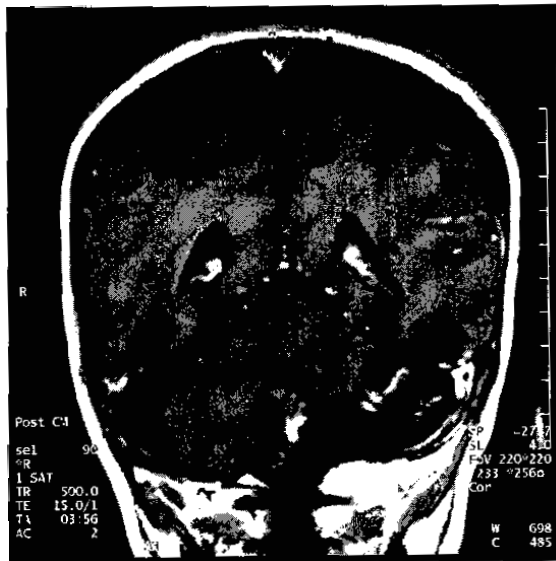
Case 3 at diagnosis: Coronal and axial MRI scans demonstrating an ependymoma involving both the third ventricle and the brainstem.
